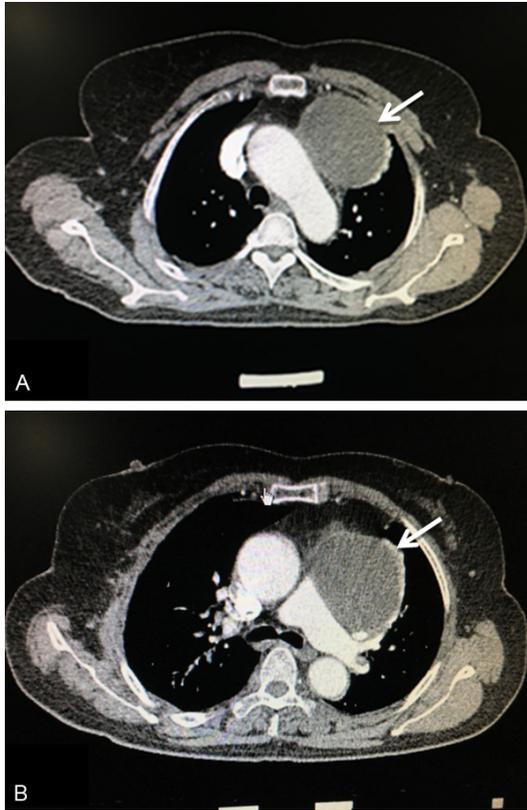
The left anterior mediastinum tumor was shown by a contrast-enhanced CT scan of the chest. A: Contrast-enhanced CT scan of the aortic arch level, with the tumor indicated by the arrow. B: Contrast-enhanced CT scan of the pulmonary artery level, the tumor indicated by the arrow.
